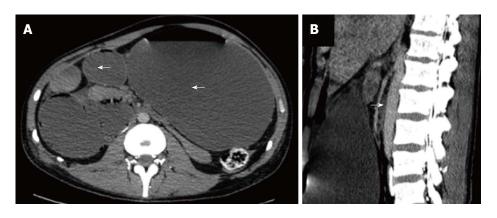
Contrast computed tomography revealing. A: A complete gastric outlet obstruction (white arrow); B: With distension of the stomach, and the duodenum, with a flat bowel after its pass behind the superior mesenteric artery (white arrow).
